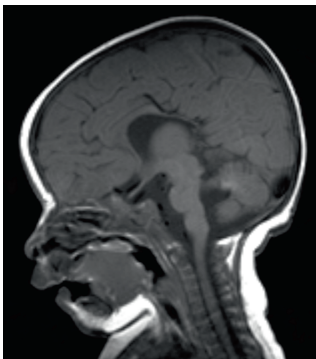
Patient 3. Sagittal T1-weighted image of a 4-month-old with 13q deletion syndrome and bilateral retinoblastoma shows agenesis of the splenium of the corpus callosum.
